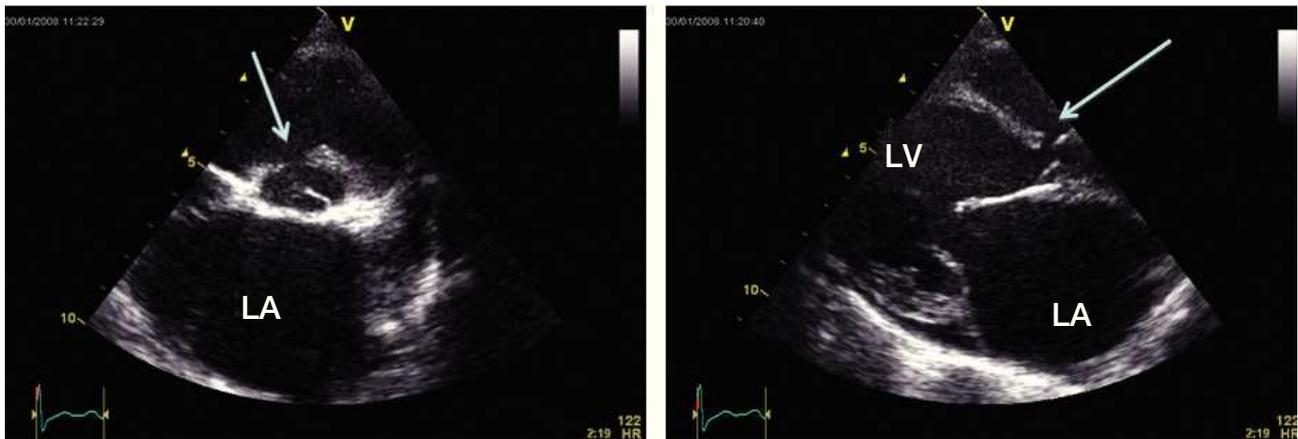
Echocardiography of a patient with a ventricular septal defects and signs of pulmonary overcirculation attesting for low pulmonary vascular resistance and high pulmonary blood flow. These pictures are usually allows for surgical repair with performing catheterization. Left pannel shows a short axis view with the ventricular septal defect defect (arrow) and in particular a dilated left atrium (LA). Right pannel shows a long axis view with a dilated left ventricle (LV) and LA attesting pulmonary overcirculation in presence of a shunt.
